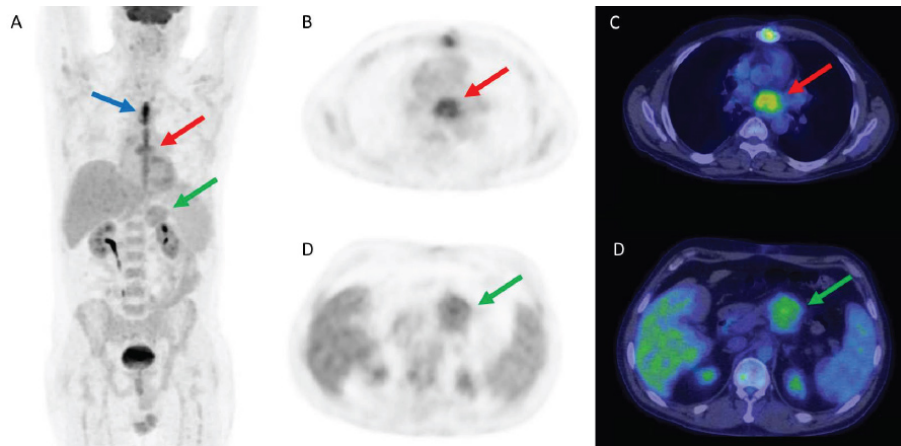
18F-FDG PET/CT MIP image (A) showed longitudinal 18F-FDG uptake in the middle of the thorax due to the recent sternotomies (blue arrow); also, in transaxial PET and fused images, mass in the left atrium was evident (B, C) and characterized by high 18F-FDG uptake (SUV max 6.8) corresponding to the sarcoma (red arrows) and a lesion with intense 18F-FDG uptake (SUVmax 5.5) in the mesogastric region (D, E) compatible with pancreatic metastasis (green arrows).
